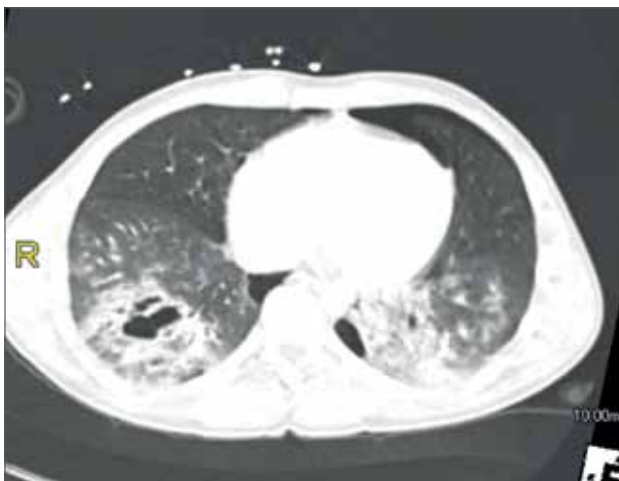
A follow-up CT on day 4 shows resolution of the ground glass opacities surrounding the cavities in the right lower lobe. There is atelectasis of the left lower lobe glass
